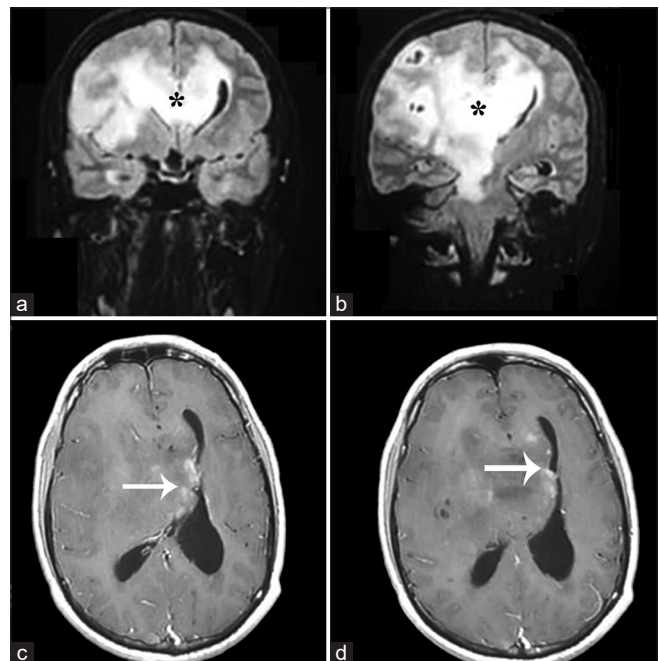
Coronal FLAIR (a and b) and postcontrast T1 (c and d) images of magnetic resonance imaging brain showing diffusely infiltrative lesion involving the corpus callosum (black asterisk in a and b) and extending to the contralateral side. Patchy lace-like enhancement was seen (white arrows in c and d); however, most of the lesions were largely nonenhancing.
